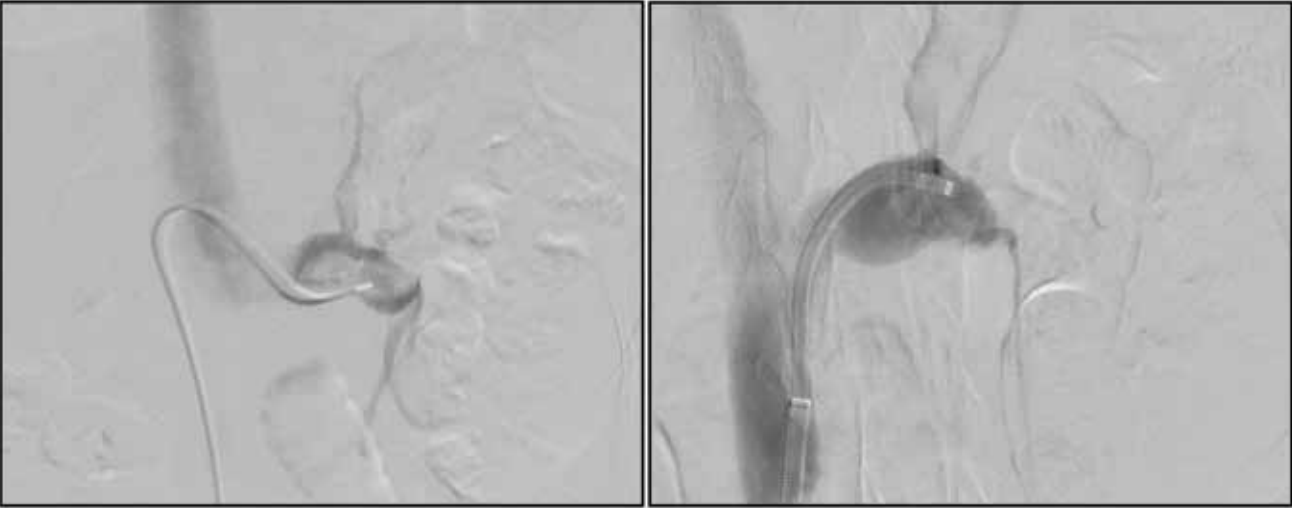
Initial venogram demonstrates extrinsic compression of the LRV with a large filling defect, concordant with thrombus (red arrow) seen on CT (left). Markedly improved vessel caliber (right) post-intervention with aspiration thrombectomy.
